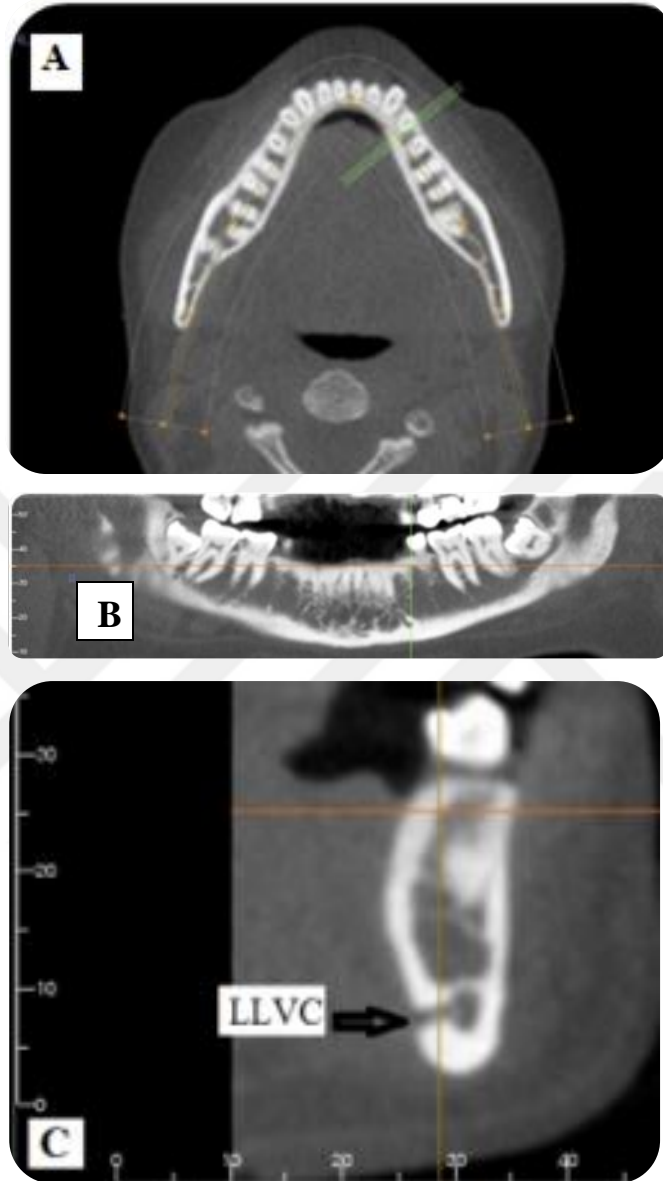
Multiplanar Reformation Arch Section. A: an axial image (cropped) with sites of cross-sections on the left side distal to the first premolar tooth. B: a reformatted panoramic view and serial cross-section 1mm-interval sites. C: a cross-sectional image, showing a lateral lingual vascular canal (LLVC) (black arrow) denoted as a radiolucent line (Images obtained with i-CAT® Model 17-19; CBCT Imaging Unit: InVivoDental5 Version 5.2 Anatomage, software); Dentomaxillofacial Radiology Department; Faculty of Dentistry- University of Yeditepe.
